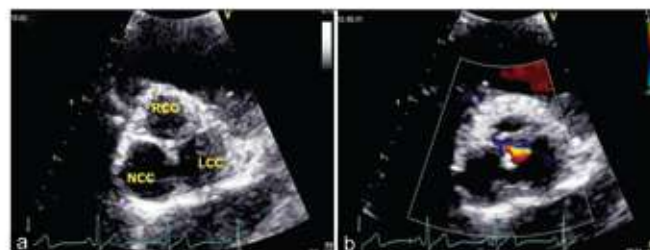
Parasternal short-axis aortic valve zoomed view; (a) two-dimensional image, (b) with color. LCC- left coronary cusp, NCC- non-coronary cusp, RCC- right coronary cusp
